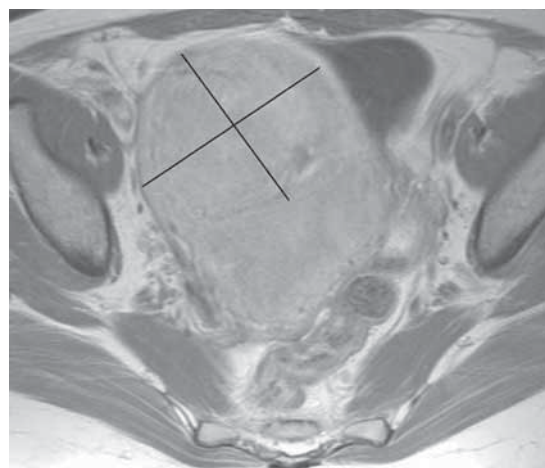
Gadolinium enhanced axial T1 weighted magnetic resonance imaging of the pelvis before embolisation. The uterus is enlarged, mainly as a result of a 14.2 cm intramural vascular fibroid, which shows pronounced enhancement
